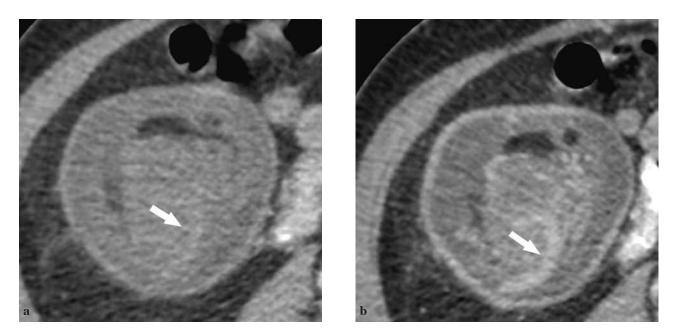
Computed tomography with intravenous contrast and water enema, showing a cecal tumor with intussusception into the proximal colon (arrow).
